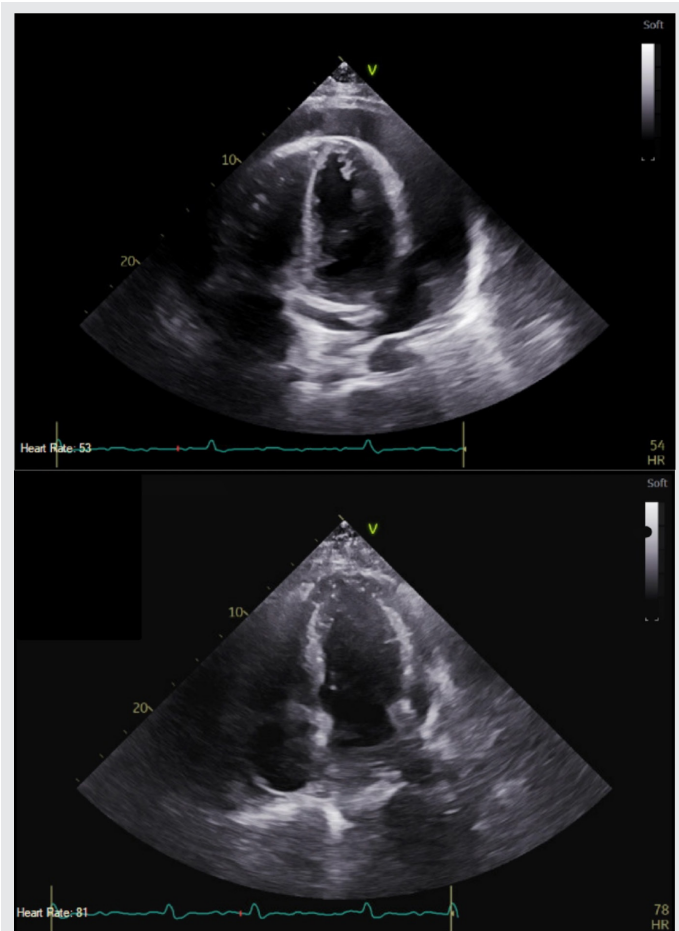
Echocardiogram before and after pericardiocentesis. Echocardiogram shows pericardial effusion before (top) and after (bottom) pericardiocentesis. The patient’s ejection fraction improved from 30% to 60% after the drainage.
